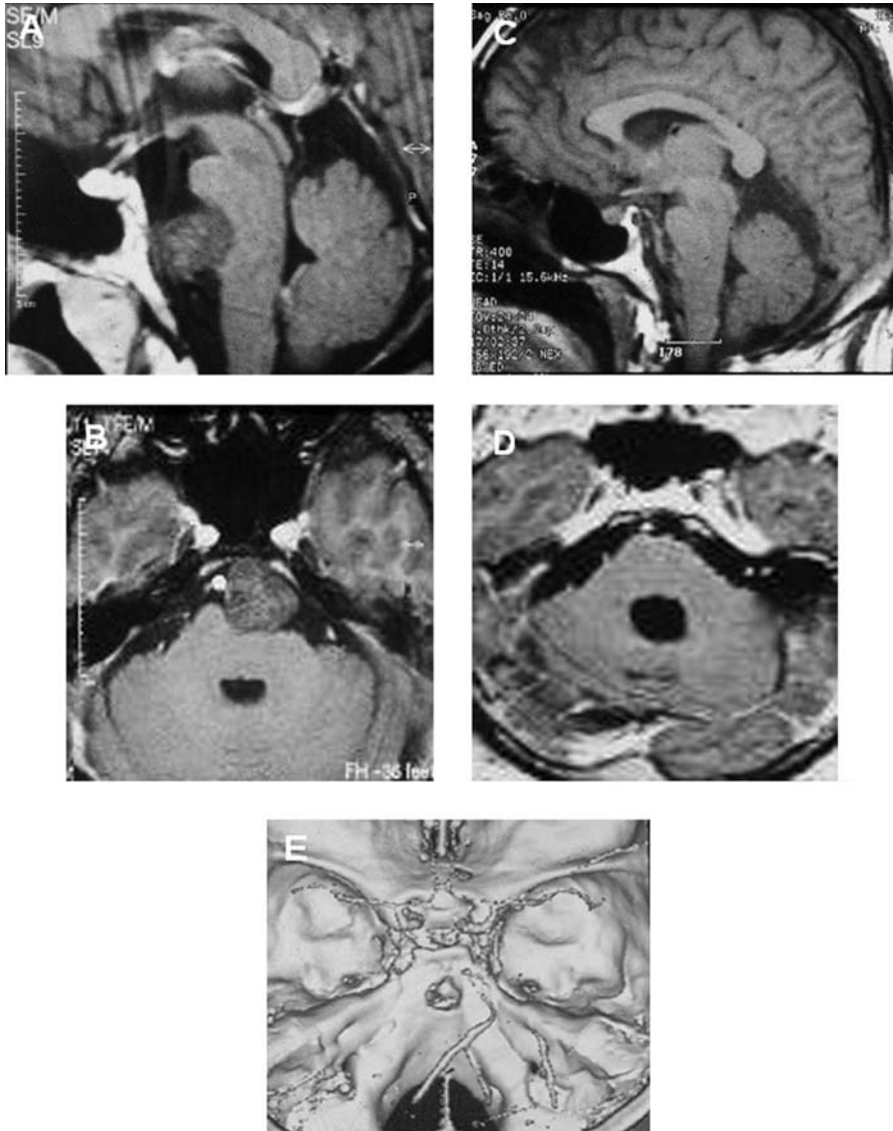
Presigmoid approach for resection of a predominantly extraosseous prepontine chordoma. A and B represent sagittal and axial preoperative T1w contrast enhanced MRI's with significant impingement on pons. C and D are the corresponding postsurgical images. E presents a preoperative CT reconstruction of skull base showing localized bone destruction at the level of mid-clivus
